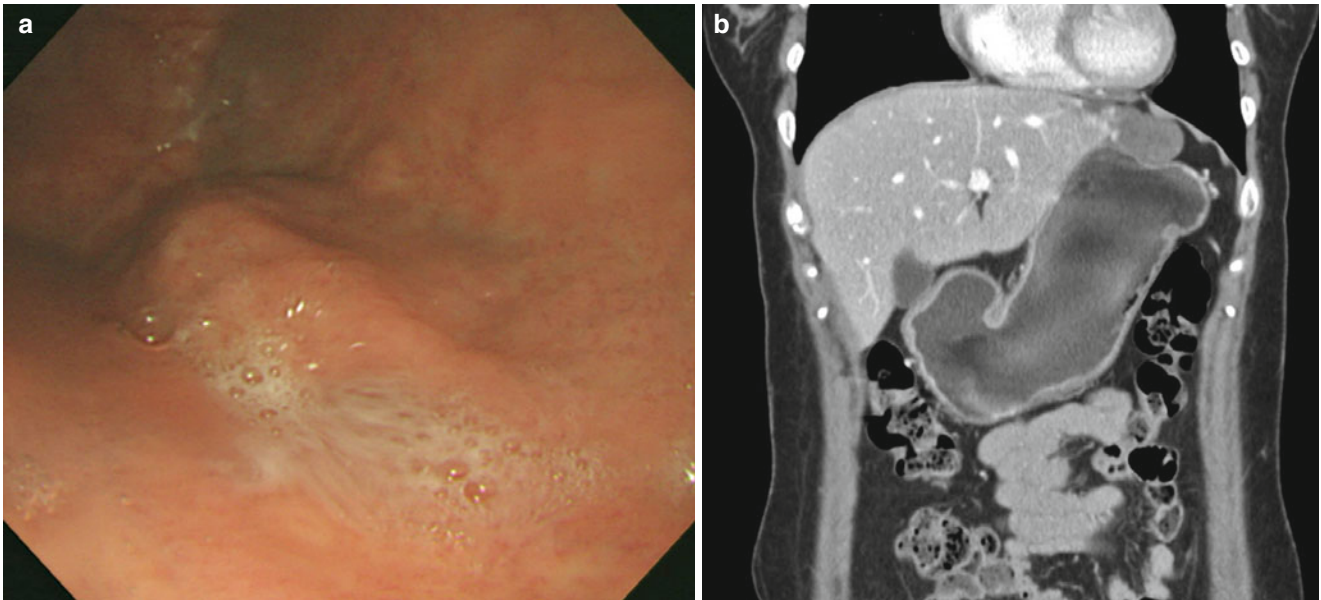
Extrinsic compression by liver hemangioma. (a) Endoscopic finding showed an intraluminal protruding lesion of the fundus, covered with normal gastric mucosa. (b) A reconstructive coronal view of CT scan revealed liver hemangioma
